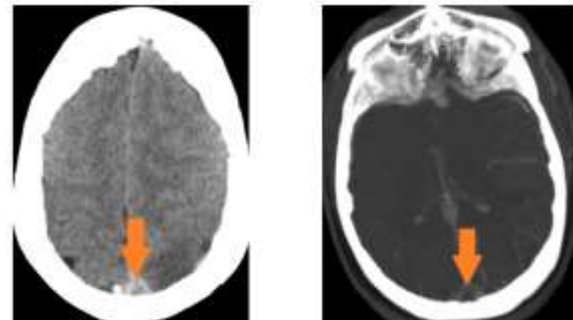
Axial non-contrast CT image: Orange arrow points to triangular filling defect in the superior sagittal sinus indicating an “empty delta sign” suggestive of cerebral venous sinus thrombosis.
